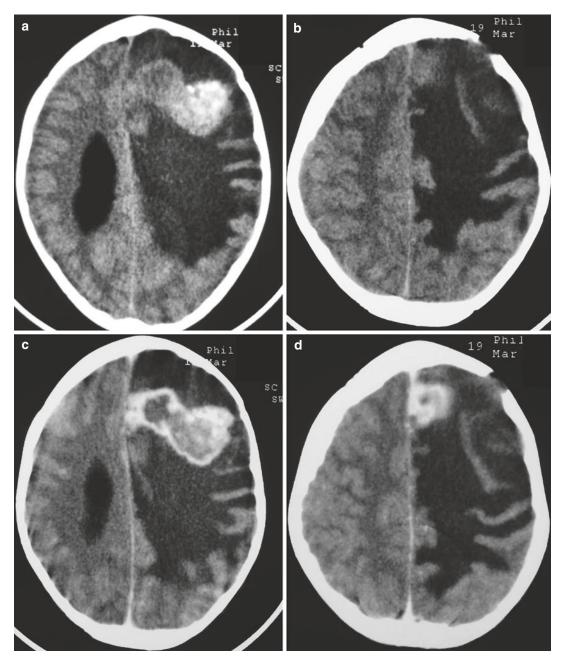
Large calcified brain tuberculoma in the *left* frontoparietal area with important perilesional edema and significant mass effect (case $n^{\circ}1$). Axial cranial CT scan before (a, b) and after contrast injection (c, d)
